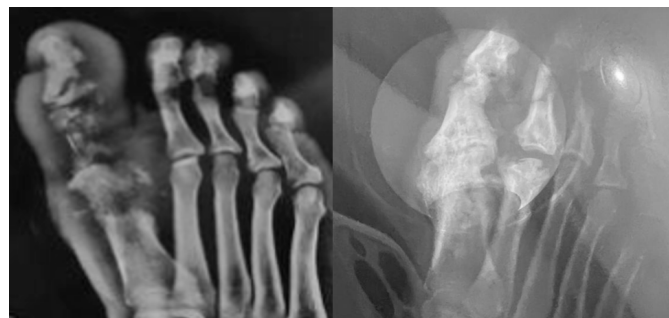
Radiographic evolution showing bone regeneration.
